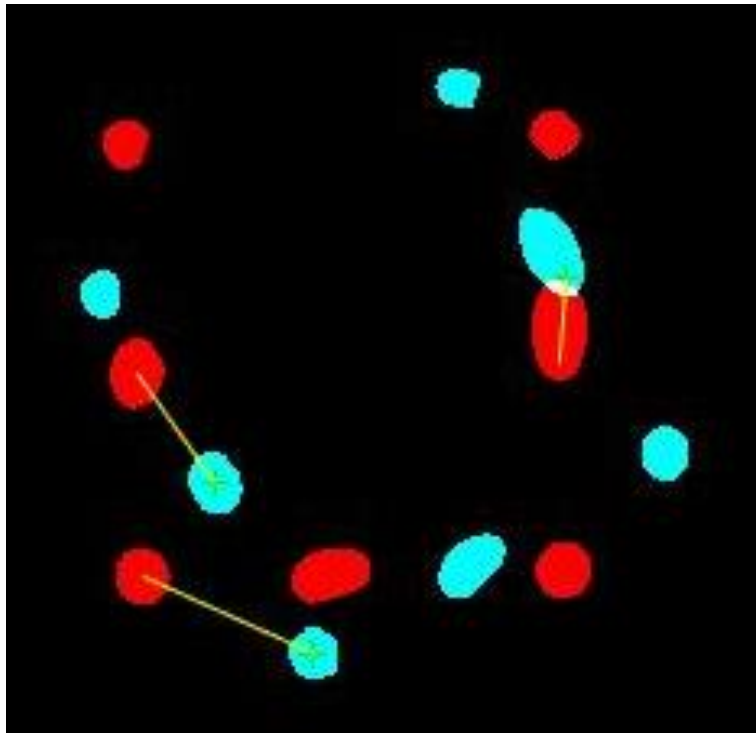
(a) Captured-MR image of the Z-frame marker (without rotation, this image is used as a reference). (b) A rotated Z-frame marker in the image, therefore the fiducials are not positioned along the U-shape of the marker. (c) Matching point pairs used in the estimation of the transformation matrix of the ellipses from the rotated image (blue ones) and the reference images (red ones). (d) The recovered image (b) after rotation.
